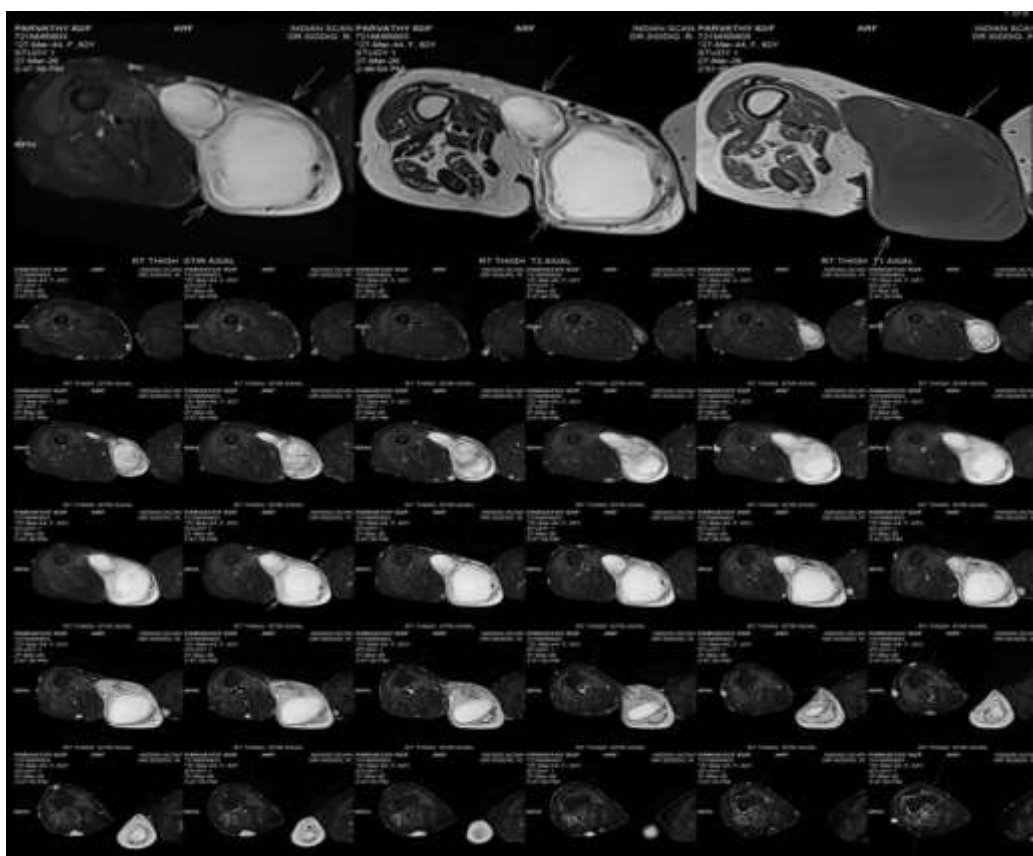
Magnetic resonance imaging (MRI) of the right thigh demonstrating a well-defined, lobulated/multilobulated exophytic subcutaneous lesion in the medial aspect of the mid-thigh, suggestive of plexiform neurofibroma or a myxomatous lesion.
